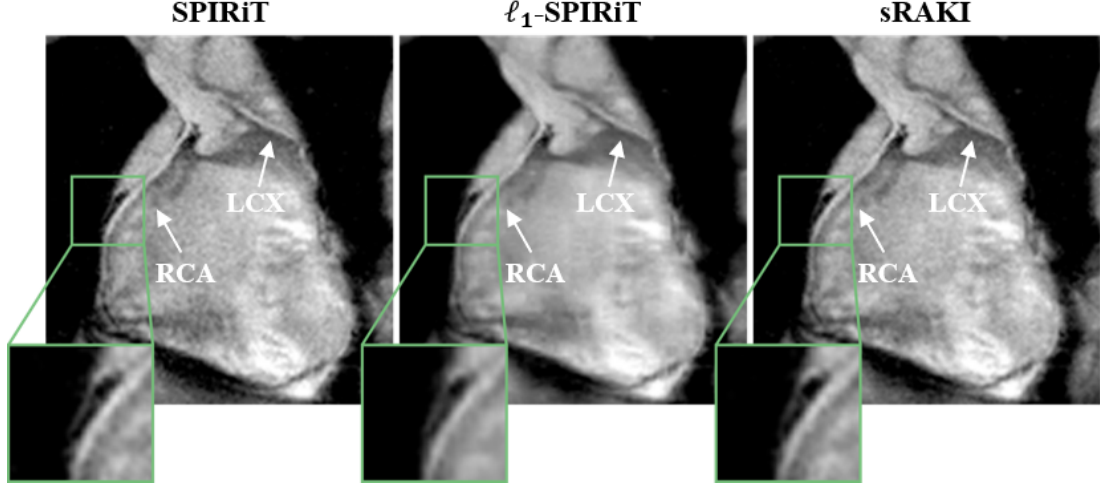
Reformatted coronal image from a prospectively 5-fold accelerated whole-heart coronary MRI dataset. The results show similar characteristics to targeted coronary MRI, where sRAKI reduces blurring with respect to l_1 -SPIRiT, and noise amplification with respect to SPIRiT.
